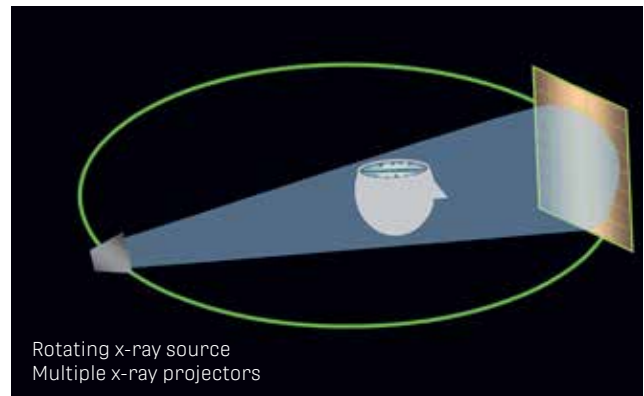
A rotating x-ray source, a flat panel detector, and a conical beam are the key components of the CBCT image acquisition process. The x-ray tube completes a full rotation around the patient's head, producing multiple exposures.
